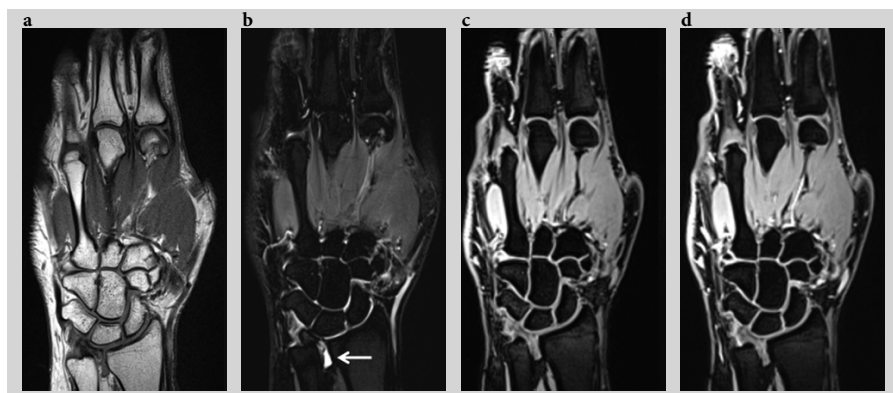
Magnetic resonance imaging (MRI) of hand and wrist in a patient with early rheumatoid arthritis in clinical and imaging remission. (a) Coronal T1-weighted; (b) short tau inversion recovery (STIR); and 3D gradient echo T1-weighted images with fat suppression before (c) and after (d) intravenous contrast injection. No synovitis, bone marrow edema, or erosions are seen; only a slight effusion in the radioulnar joint (arrow). Note the homogenous shape and signal from the joint spaces in the visualized wrist and metacarpophalangeal joints, indicating normal cartilage.
